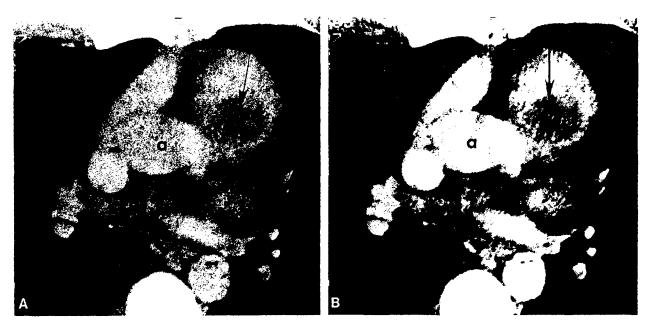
A CT scan through level of aortic root (a) demonstrates a 2.5-cm mass in pulmonary artery (arrow). B Image at narrow window setting demonstrates the apparent nodularity of the mass.
